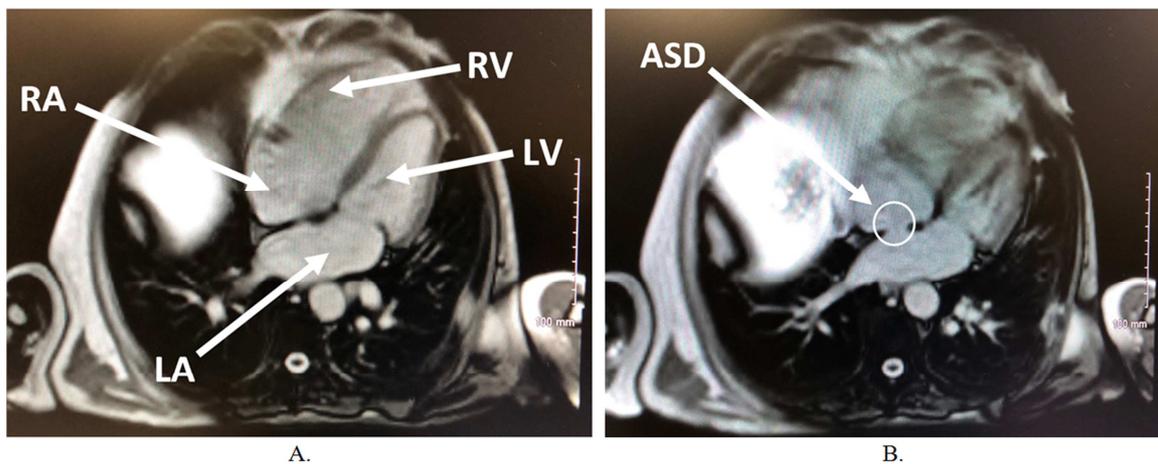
Images from Cardiac Magnetic Resonance Imaging.
